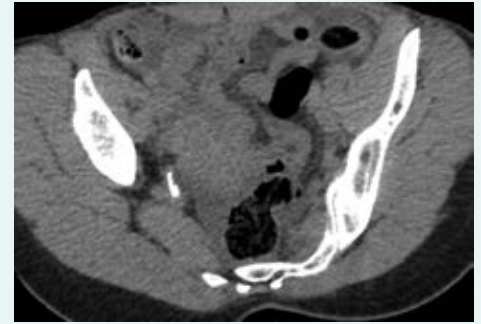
Axial non-contrast computed tomography image through the pelvis
